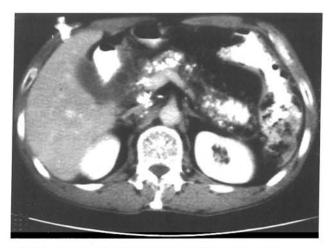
Mesenteric lymph node enlargement on CT
